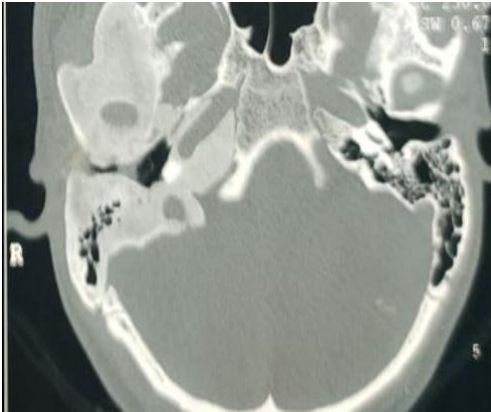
HRCT temporal bone showing expansion of diploic space involving right temporal bone extending in mastoid process and petrous part. There is ground glass appearance of stroma with partial obliteration of right mastoid air cells suggestive of fibrous dysplasia. There is mild narrowing of internal auditory canal. Right external auditory canal is narrow in mid part.
